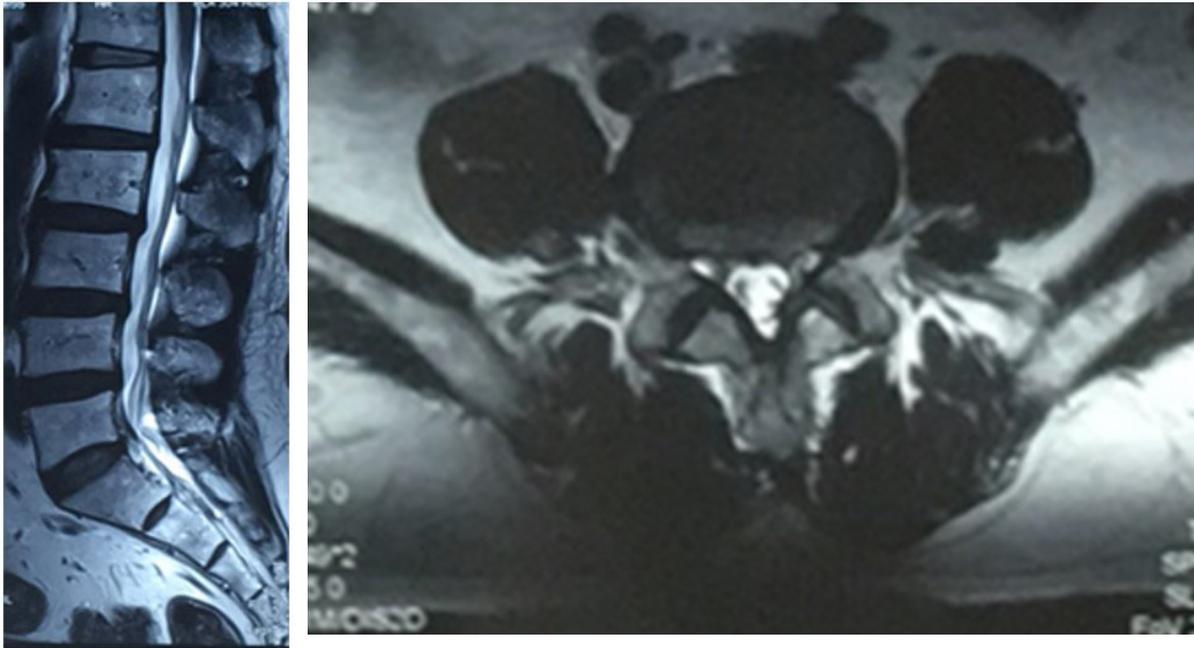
MRI shows some kind of lumbar disc herniation (L4-5) and stenosis.
